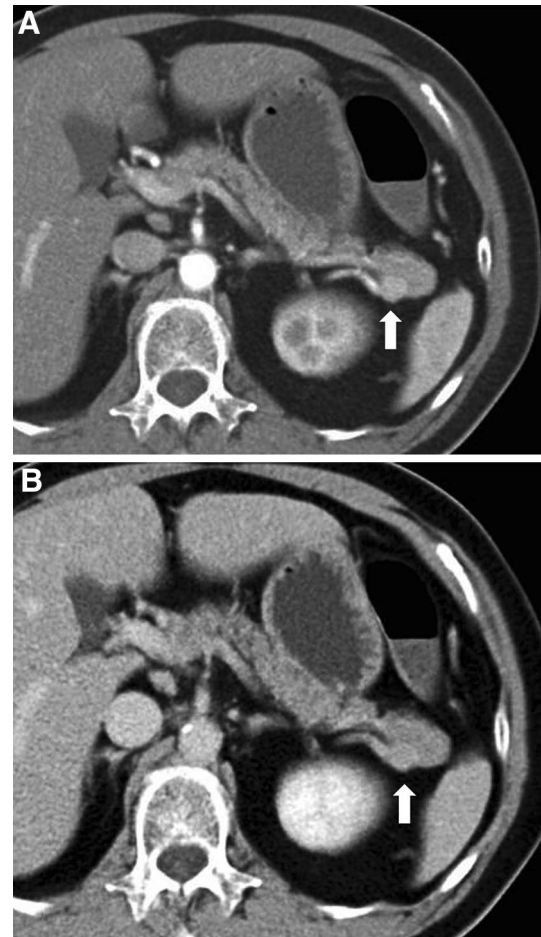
A 40-year-old man with abdominal pain and vomiting. Axial CT images on arterial (a) and portal venous phase (b), show well-circumscribed rounded nodule at pancreatic tail (*arrow*), with similar enhancement to the native or anatomical spleen
